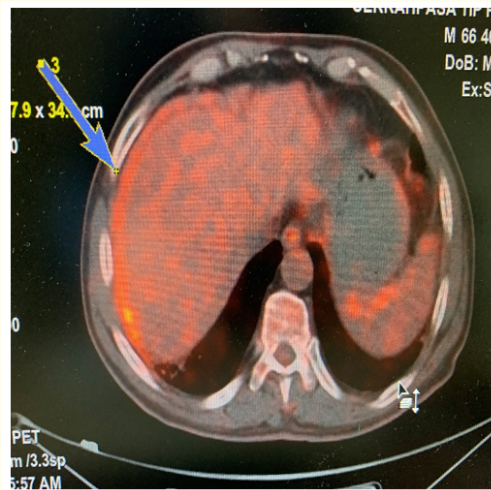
PET/CT demonstrated increased FDG uptake over the hepatosplenic surface areas.
